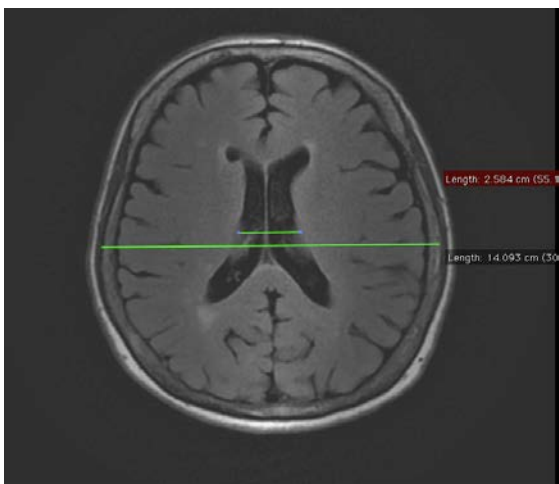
FLAIR Axial Slice Brain MRI Cella Media Index 5.4 and Fazekas Scale 0
